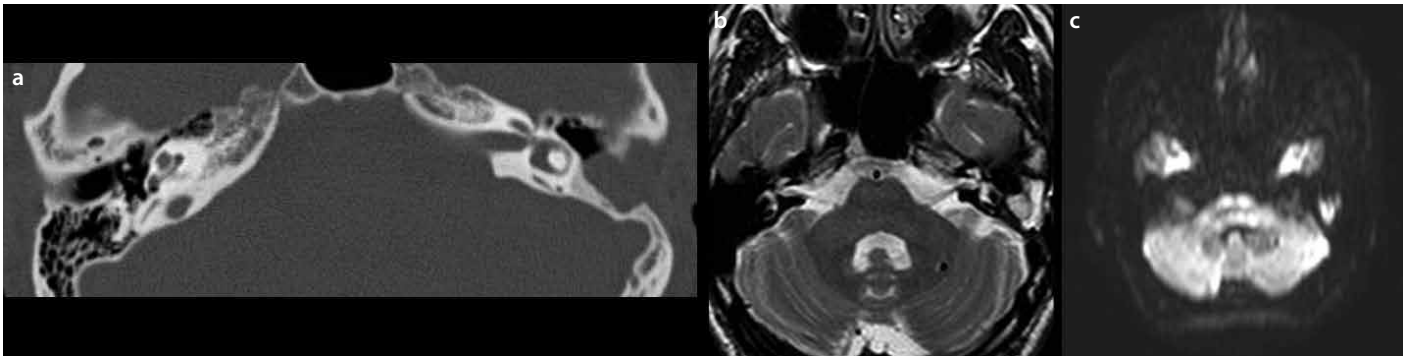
a-c. a. CT of soft tissue density in the operated cavity. b. MRI-T2 of soft tissue density in the operated cavity. c. DW-MRI of a hyper-intense signal in the mastoidectomy cavity
